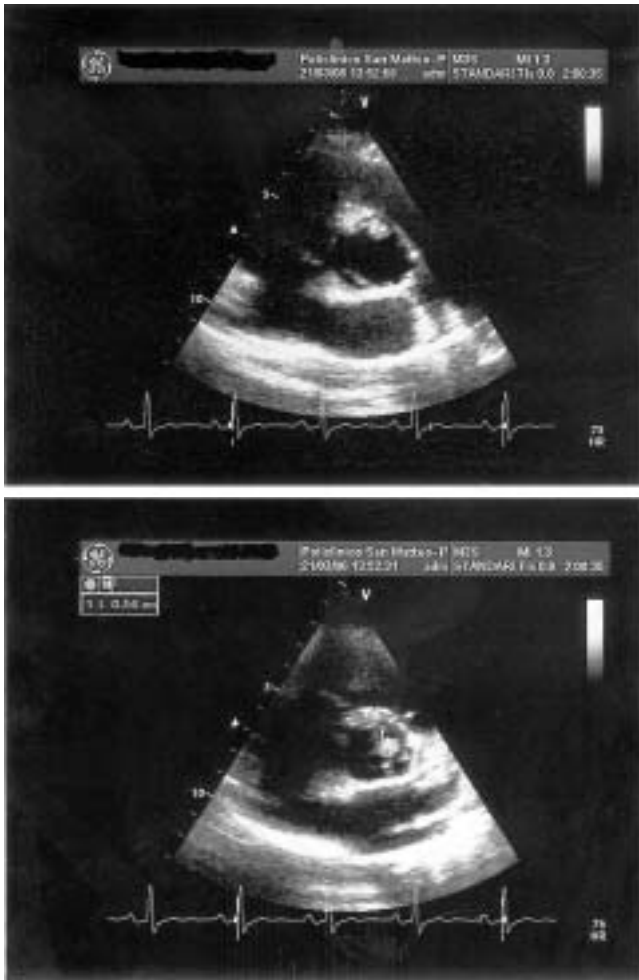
Transthoracic echocardiography showing (in parasternal view) the tumor on the right coronary cusp in diastole (upper) and systole (lower).
